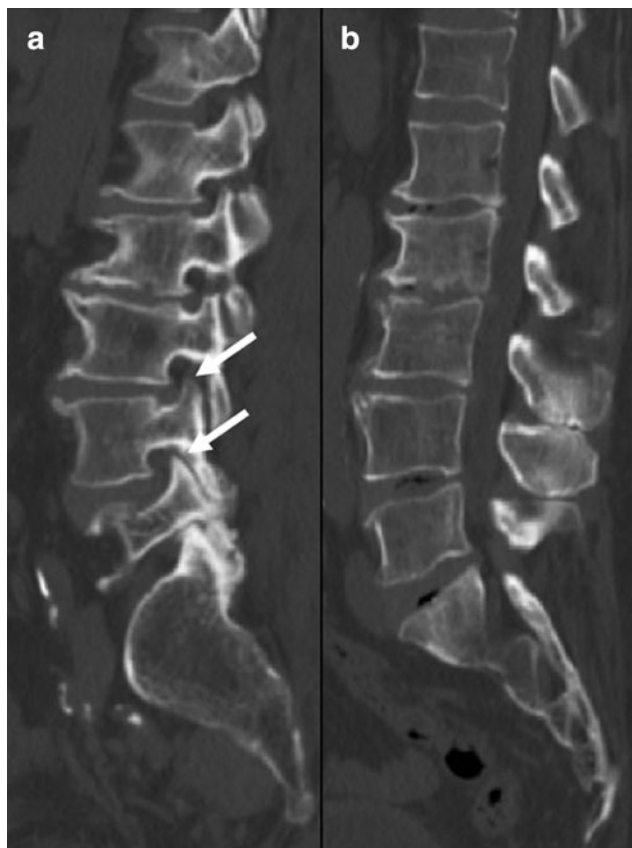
Preoperative images for patient described. (a) Sagittal computed tomography (CT) image showing the left neural foramina. The foramina at L3–4 and L4–5 appear significantly compressed, as demarcated by white arrows. (b) Sagittal CT image showing the spinal canal at its greatest diameter. Degenerative disk disease is seen with collapsed disk spaces at L2–3, L3–4, and L4–5.
